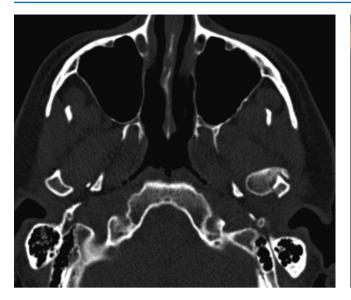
Fracture dislocations of the head require careful assessment. Plain films often do not show the true extent of injury. In this case the head appears fragmented
